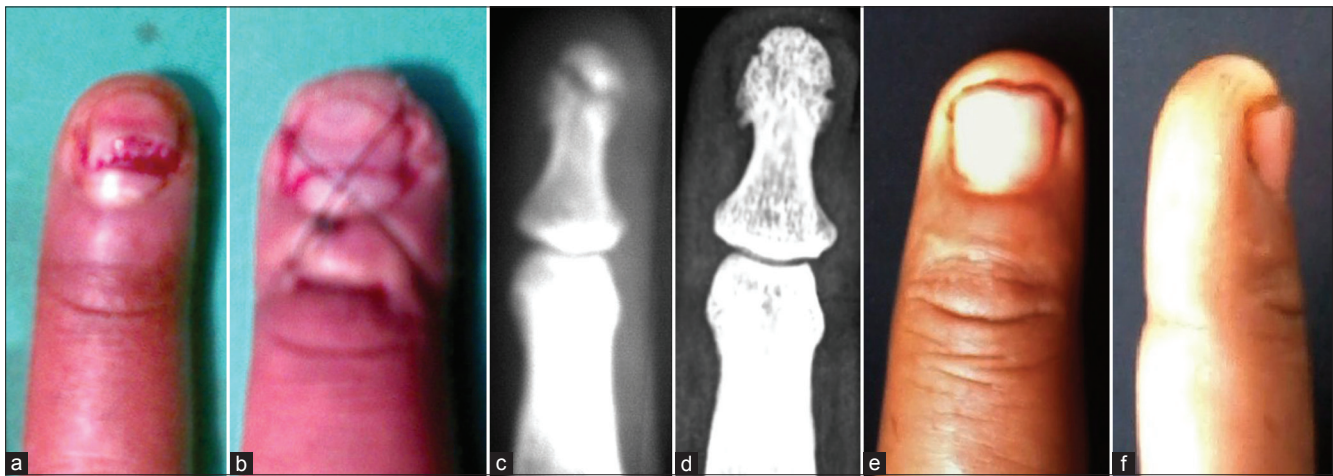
Clinical photographs (a,b,e,f) and X-rays anteroposterior view (c,d) shows (a) A 35-year-old patient with sharp injury through the nail. (b) Vertical figure-of-eight suture placed dorsally over the nail. (c) Fractured distal phalanx. (d) Healed distal phalanx at 2 years. (e and f) Clinically stable fingertip at 2 years
